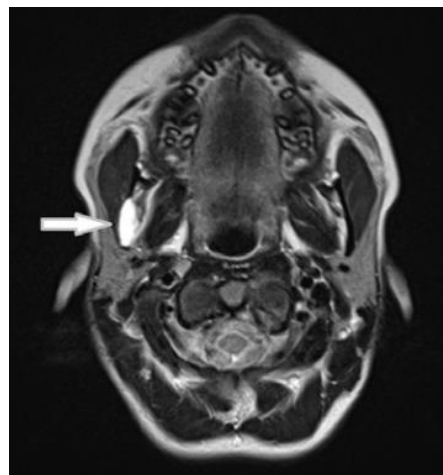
MRI showing a well-defined solitary bone cyst lesion in the right mandibular ramus [45].
